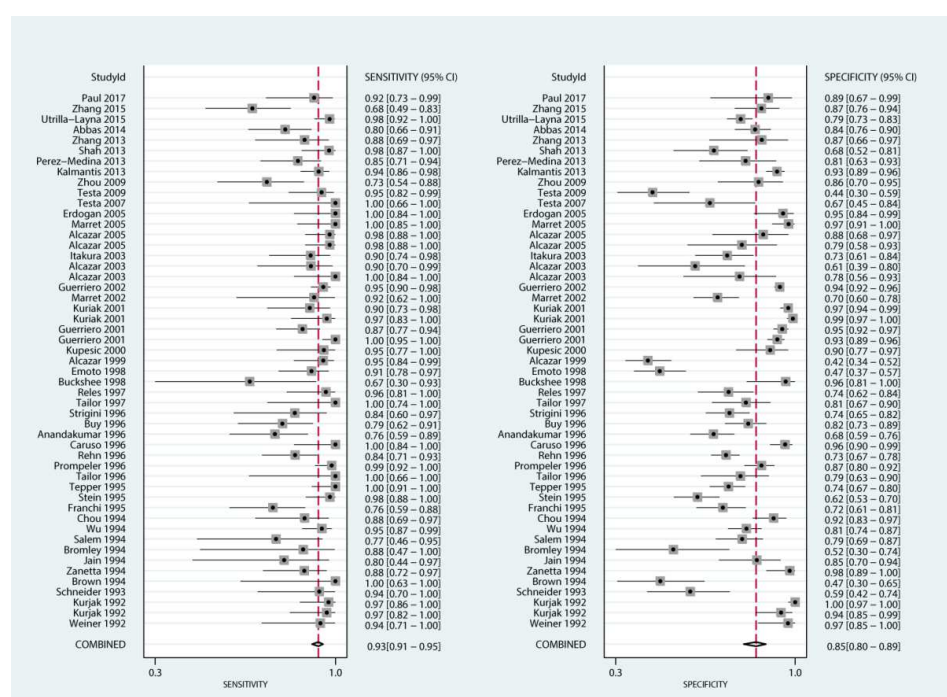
The pooled sensitivity and specificity for Doppler US differentiate the benign and malignant ovarian masses
